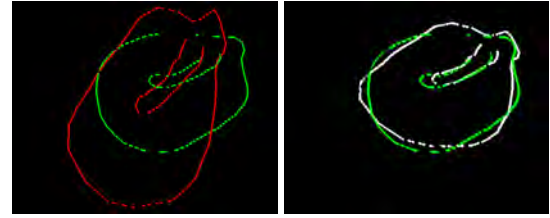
Red: CT initial moving point cloud position.
